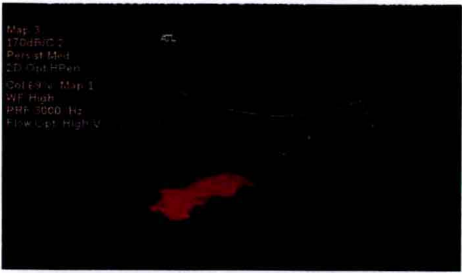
Duplex ultrasound of the abdominal aorta in the same patient as in Figure 2.2. Top panel: Color image demonstrating occluded infra-renal aorta. Bottom panel: Doppler analysis demonstrating preocclusive “thump” characteristic of occlusion.
